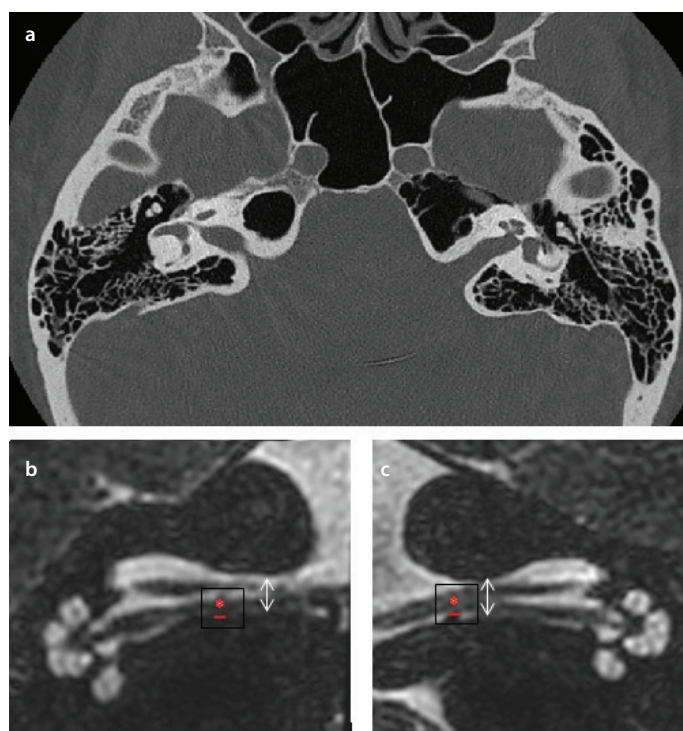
a-c. a) Temporal bone high-resolution computed tomography (HRCT) in axial plane showing hyperpneumatization of the petrous bone at the level of IAC. b) and c) T2 weighted HR DRIVE (3T MRI, Ingenia, Philips) Reduced vertical diameters (white arrow) of both IAC (a) right-hand side; b) left-hand side. Red cross: cochleo-vestibular nerve in direct contact on more than 3.6 mm with the inferior wall of the IAC. Note that only a slight and limited contact was found on the left-hand side.
